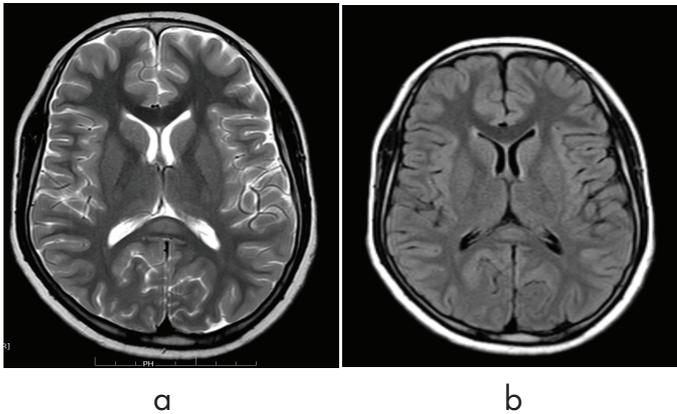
a) T2 weighted axial MRI shows an ill defined, hyperintense lesion in the splenium of corpus callosum b) The lesion appears partly suppressed on FLAIR sequence.
